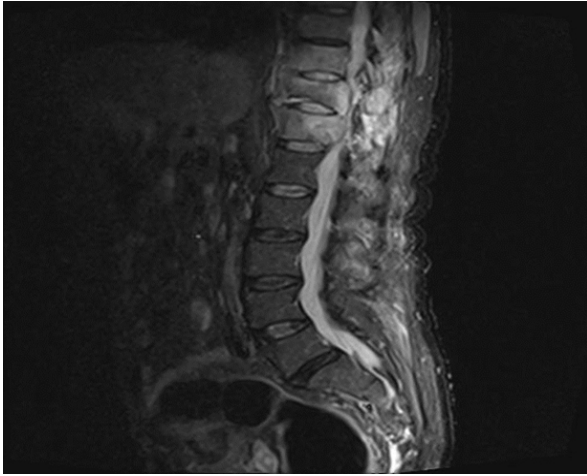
A sagittal T2W MRI showing diffuse hyperintense abnormal signals within D11 and D12 vertebral bodies predominantly along posterior corners, extending into the posterior element.
